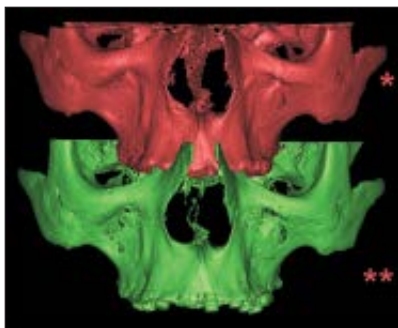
The overlapping of (red) preoperative 3D representations of maxillary CT images and (green) postoperative imaging using Mimics software.
